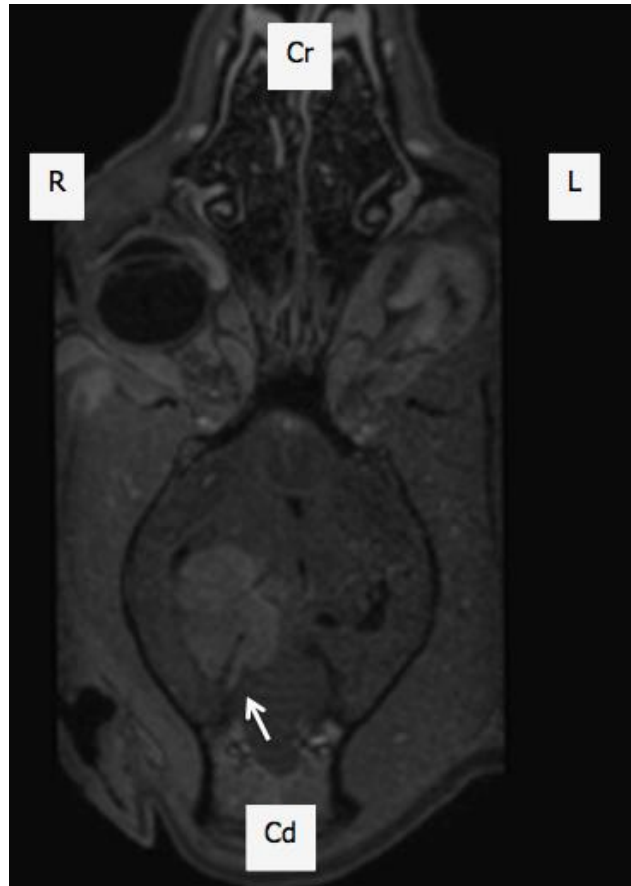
Dorsal contrast MRI of a 7-yr-old female leopard (*Panthera pardus fusca*) showing homogenous enhancement of an intra-cranial mass with a dural tail at the right tentorial region (white arrow), indicating a possible meningioma. Orientation of dorsal images is denoted by Cr= cranial, Cd= caudal, R=right and L=left
